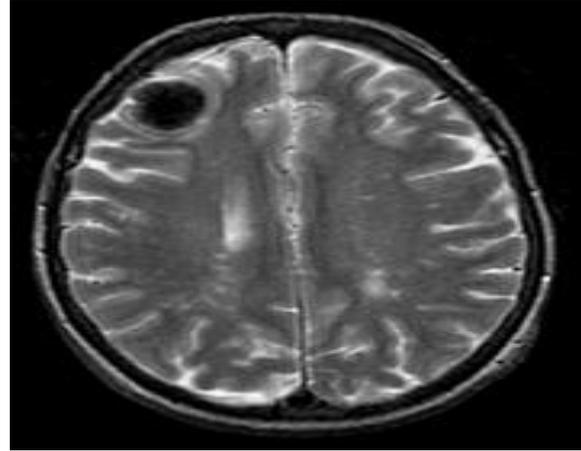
The MRI shows a lesion in the right second frontal convolution and another in the cerebellum, close to the fourth ventricle, as observed on the sagittal image as well. Both lesions display heightened contrast enhancement along their borders. Metastatic brain lesions typically occur as more than one, although they are not consistently multiple. The T2 weighted images show a mild signal in the frontal cortical structure. Alternatively, a cerebellar injury can result in considerable swelling and potentially displace the underlying brainstem, posing a risk as it is close to vital brainstem centers that regulate important functions such as breathing. This injury required immediate attention and careful monitoring.
